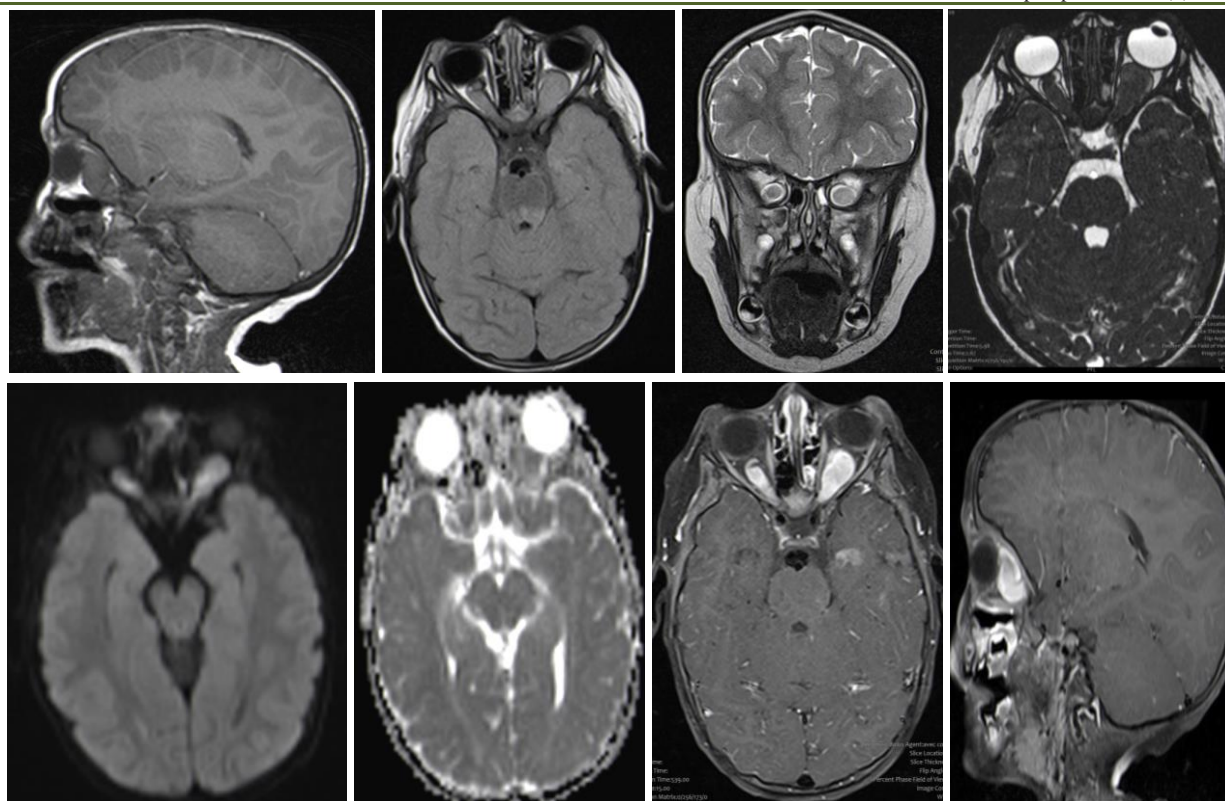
Cerebral MRI in T1 axial, T2 coronal, diffusion and T1 3D sequence after injection of Gadolinium: regular well-limited fusiform thickening of the optic nerves in T1 isosignal, intermediate in T2 and FLAIR, in diffusion hypersignal without ADC restriction, intensely and finely heterogeneously enhancing after injection of contrast medium. This thickening is responsible for a grade I left exophthalmos, with widening of the optic canals posteriorly and filling of the intraconical fat
